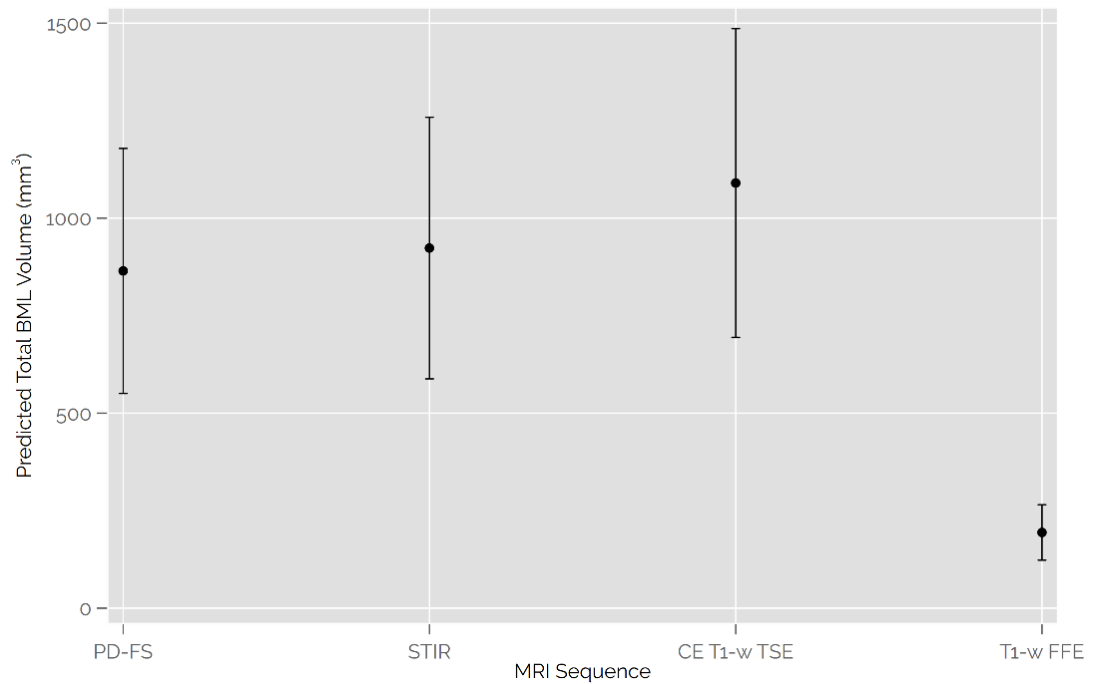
Comparison of BML volumes between MRI pulse sequences, taken from the panel linear regression model, after back-transformation onto the  $\text{mm}^3$  scale.
